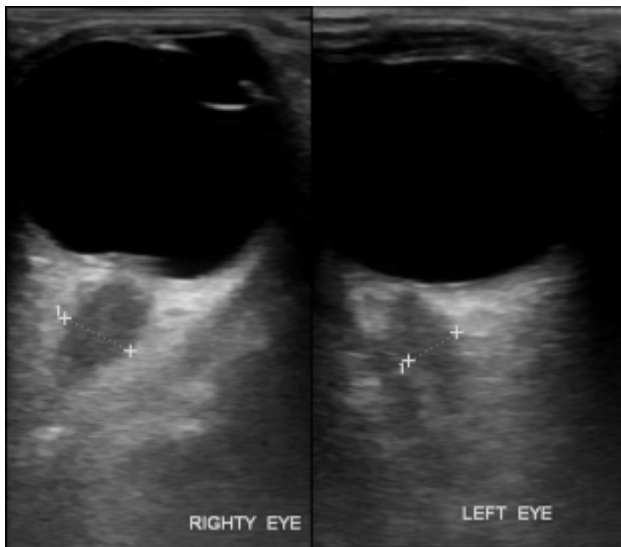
Ultrasound image of both eyes shows thickened and tortuous optic nerves and elevation of right optic disc
